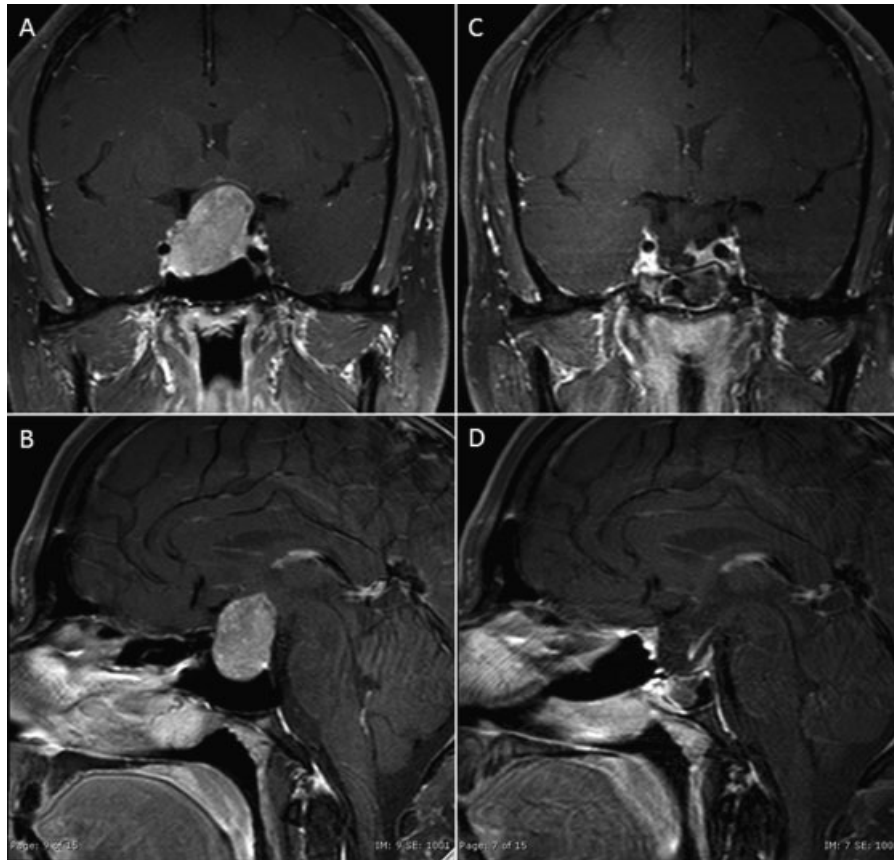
Case 1. (A, B) Preoperative T1-weighted images with gadolinium demonstrating a hypoenhancing sellar and suprasellar mass with significant optic chiasmal compression and right cavernous sinus invasion. (C, D) Three-month postoperative images demonstrate no evidence of residual or recurrence.
